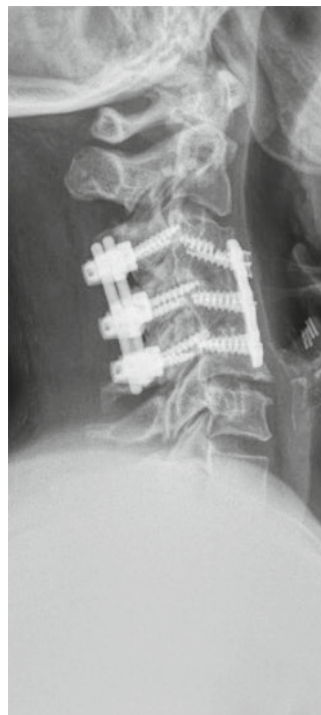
One-year follow-up upright neutral lateral cervical radiograph with evidence of successful arthrodesis of the facet and interbody space at C3/C4 and C4/C5
